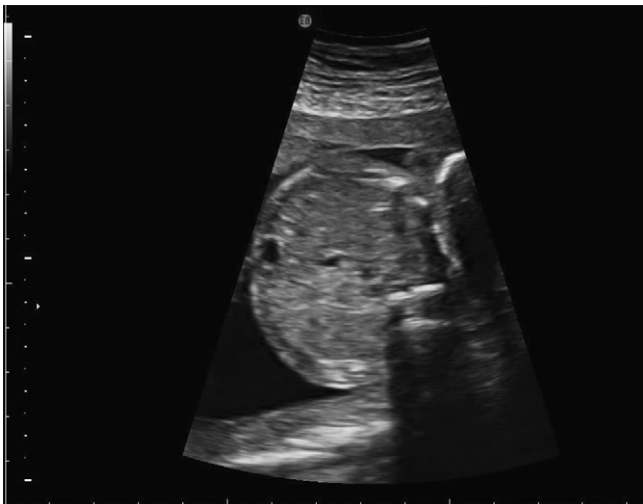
Prenatal ultrasound demonstration of absent stomach.
